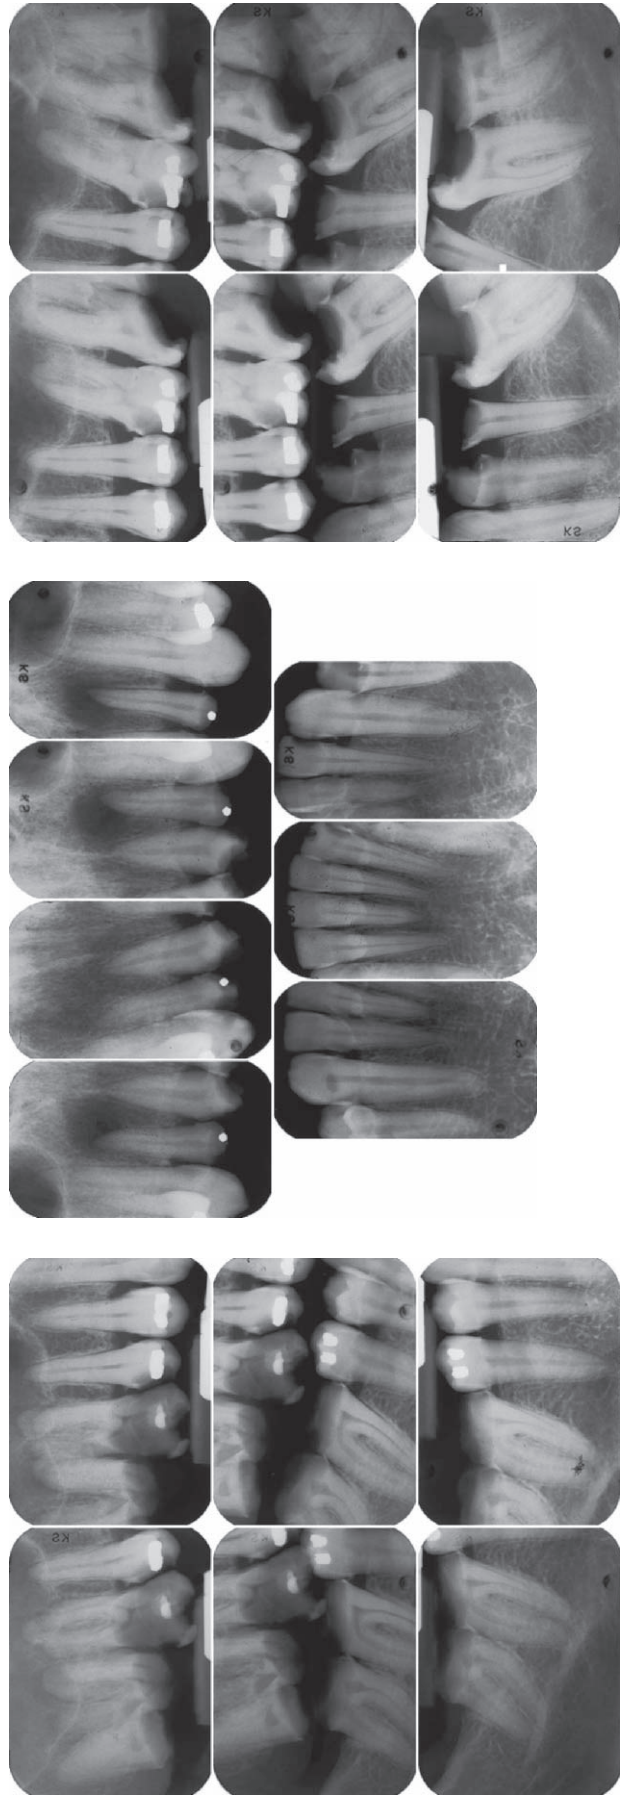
A 19-film complete mouth survey (CMS) consisting of 15 periapical and 4 bite-wing radiographs. The patient exhibits radiographic signs of rampant dental caries and a pulpal pathology.
